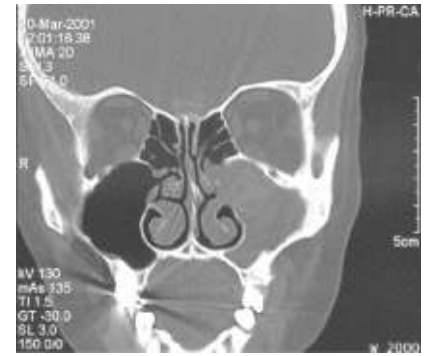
Sinusitis. Coronal CT image shows an opacified left maxillary sinus and marked associated bony thickening, consistent with chronic maxillary sinusitis. (Reproduced with permission from Lalwani AK. *Current Diagnosis & Treatment in Otolaryngology—Head and Neck Surgery*, 2nd ed. New York, NY: McGraw-Hill; 2008.)
